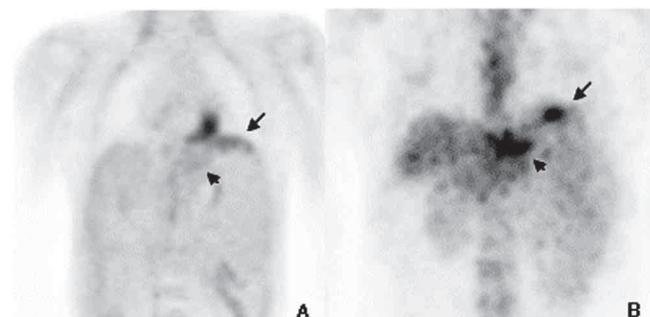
(A) FDG PET image and (B) ^{67}Ga image for a 46-year-old male patient (patient #4). Image (A) shows abnormal FDG uptake in left subphrenic area (arrow) with recurrent viable tumors confirmed by the follow-up CI. The 3 cm lesion in left liver lobe (arrow head) is not observable on image (A). Image (B) reveals increased ^{67}Ga uptake in both arrowed areas.
